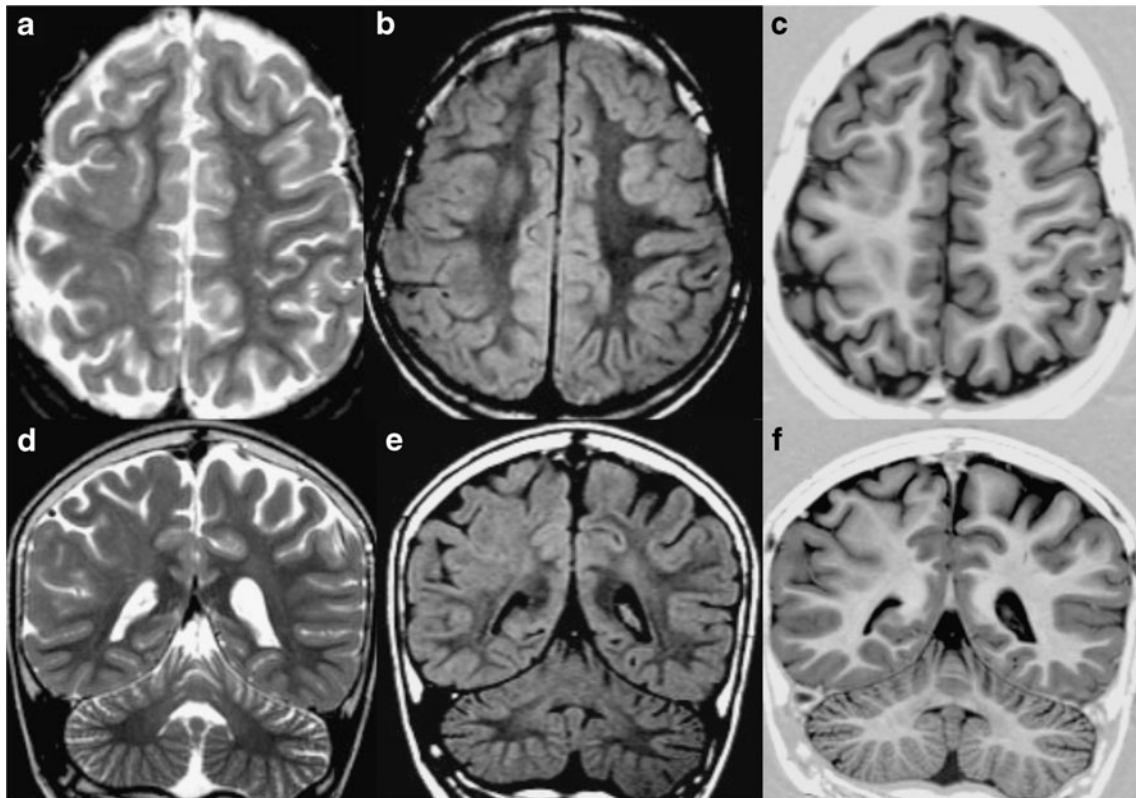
FCD IIa: a, b, c axial TSE-T2WI, FLAIR-T2WI and IR-T1WI, d, e, f coronal TSE-T2WI, FLAIR-T2WI, and IR-T1WI. In the right fronto-parietal region, the cortex appears thickened, with abnormal gyration and blurred demarcation with the white matter, both on
